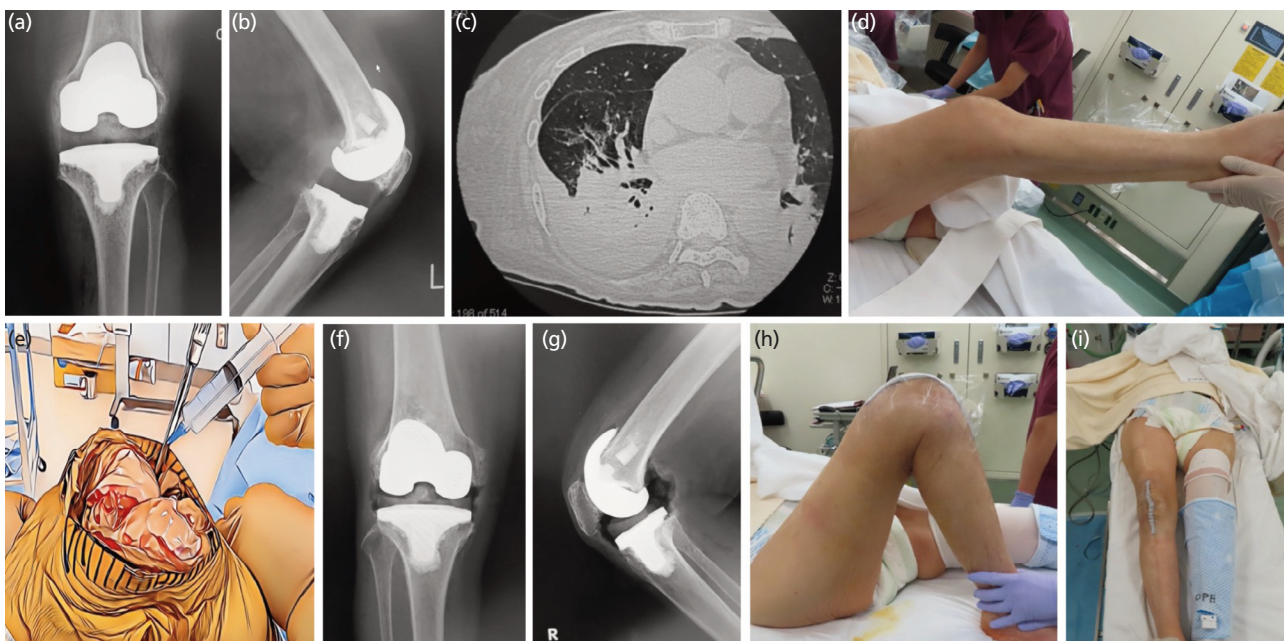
On the 7th post-operative day, left knee radiographs and chest computed tomography (were taken CT) under general anaesthesia. Subsequently, right knee post-operative radiograph under local anaesthesia and chest CT on post-operative day 7 during 28 days of hospitalisation. (a) Left knee radiograph after operation front view. (b) Left knee radiograph after operation lateral view. (c) Immediately before R.TKA She caused heart failure at another hospital. (d) Pre-operative right knee under no anaesthesia. Right knee has become stiffer due to long-term bed rest. ROM was 30° – 35°. (e) Right knee joint under local anaesthesia image. (f) Right knee radiograph after operation front view. (g) Right knee radiograph after operation lateral view. (h) Post-operative right knee flexion under local anaesthesia. (i) Post-operative right knee extension under local anaesthesia.
